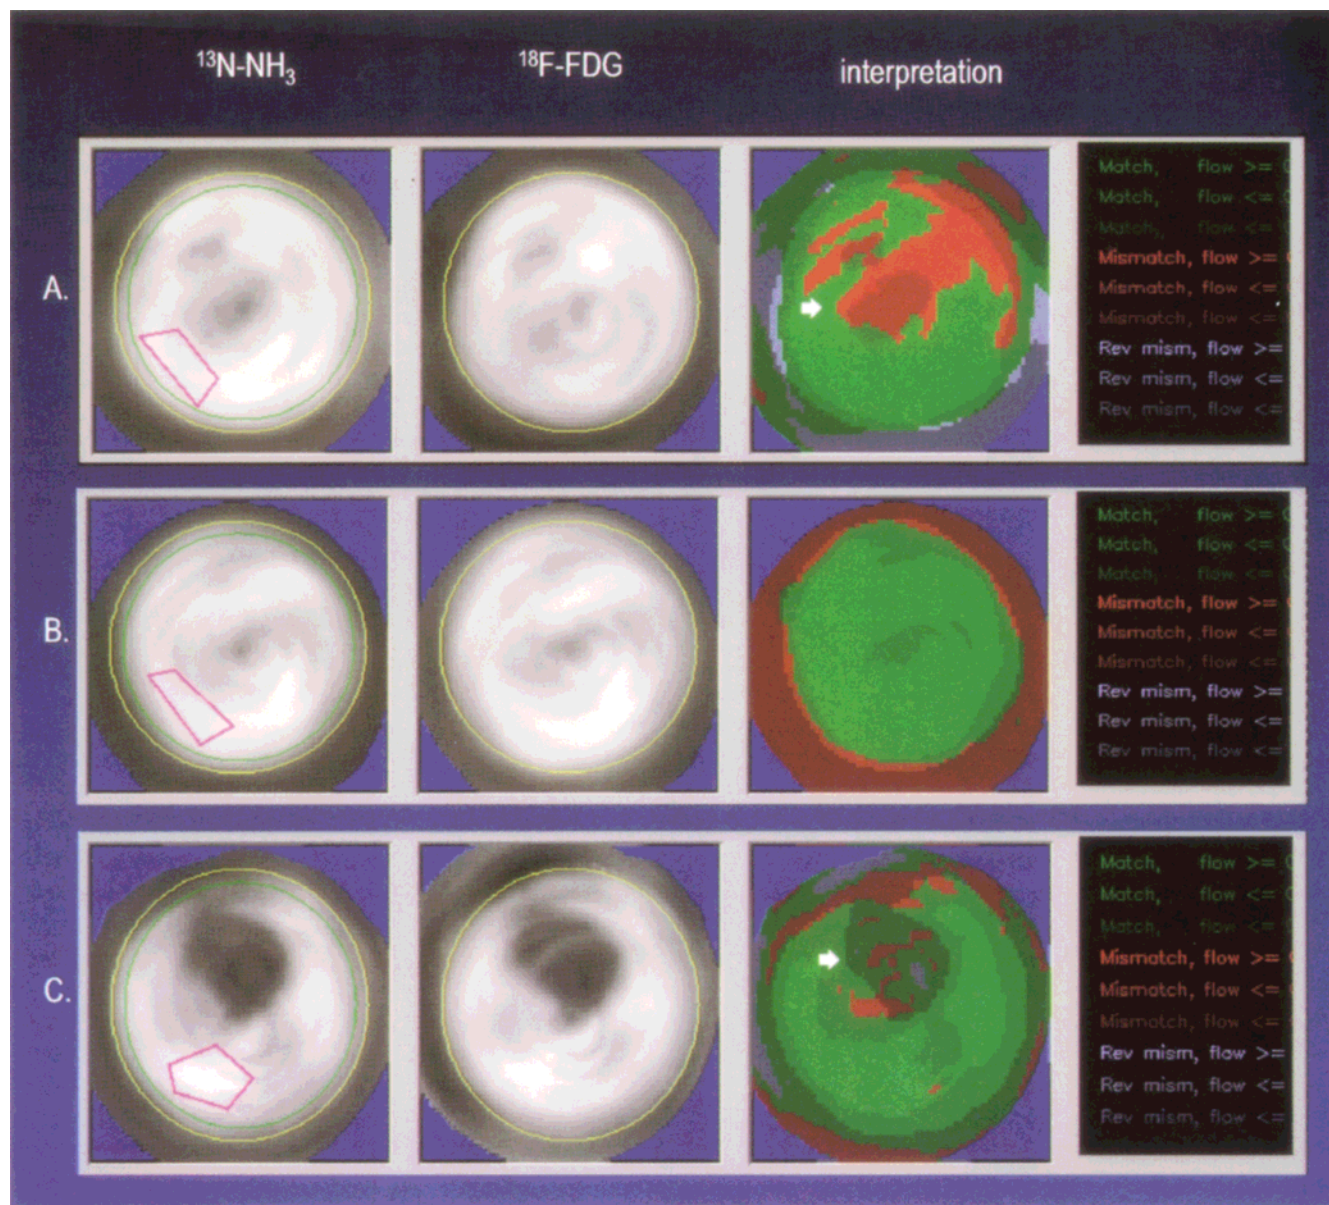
Three cases of hypokinesia of the anterior wall. The first map of each case represents the $^{13}\text{N-NH}_3$ uptake, the second the $^{18}\text{F-FDG}$ uptake and the third map is the interpretation image. Relative $^{13}\text{N-NH}_3$ uptake is coded as intensity and the combined pattern in color. (A) Decreased flow and preserved metabolism in the anterior wall. The interpretation image shows PET mismatch, represented in red (arrow). The patient had viable myocardial tissue. (B) Normal flow and normal metabolism. The interpretation image shows PET match normal (viable), represented in green. (C) Severely reduced flow and metabolism in the anterior wall. The interpretation shows PET match represented in dark green (arrow). This patient had necrosis of the myocardial tissue that is not viable.
